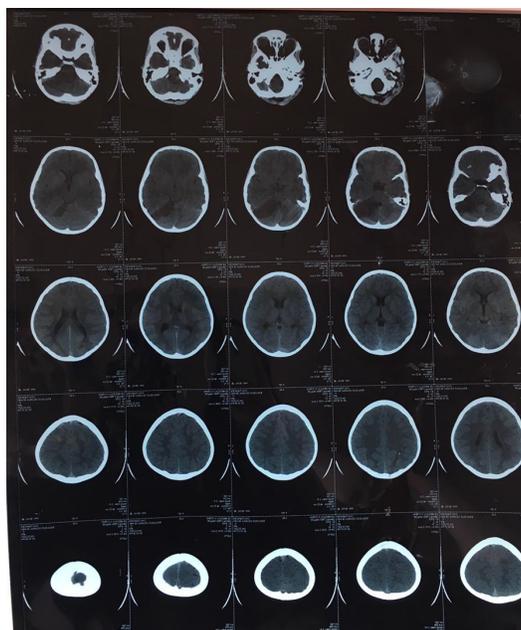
Magnetic resonance imaging of the brain that confirm an established stroke.
